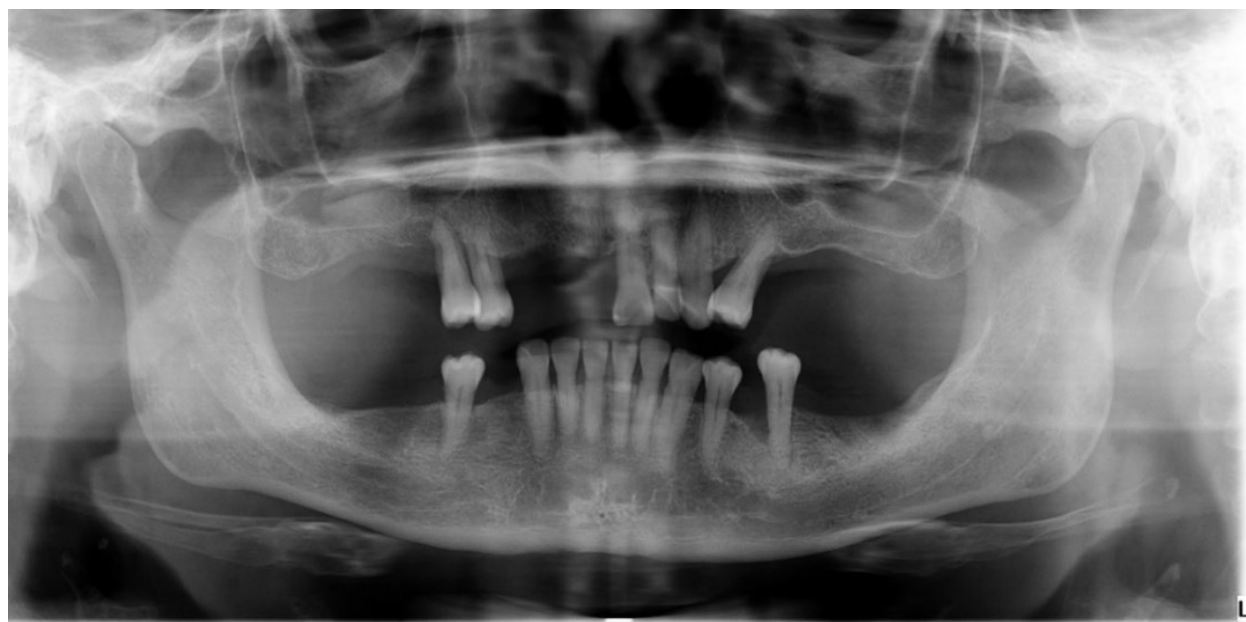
Baseline panoramic radiograph of the patient showing generalized horizontal bone loss and vertical bone loss on mesial root surface of lower left second premolar tooth
